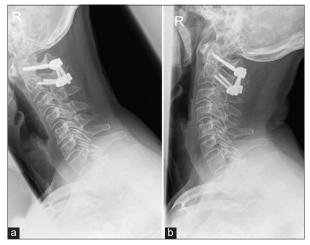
Flexion (a) and extension (b) cervical spine X-ray at 3 months follow-up shows absence of C1-C2 instability.
